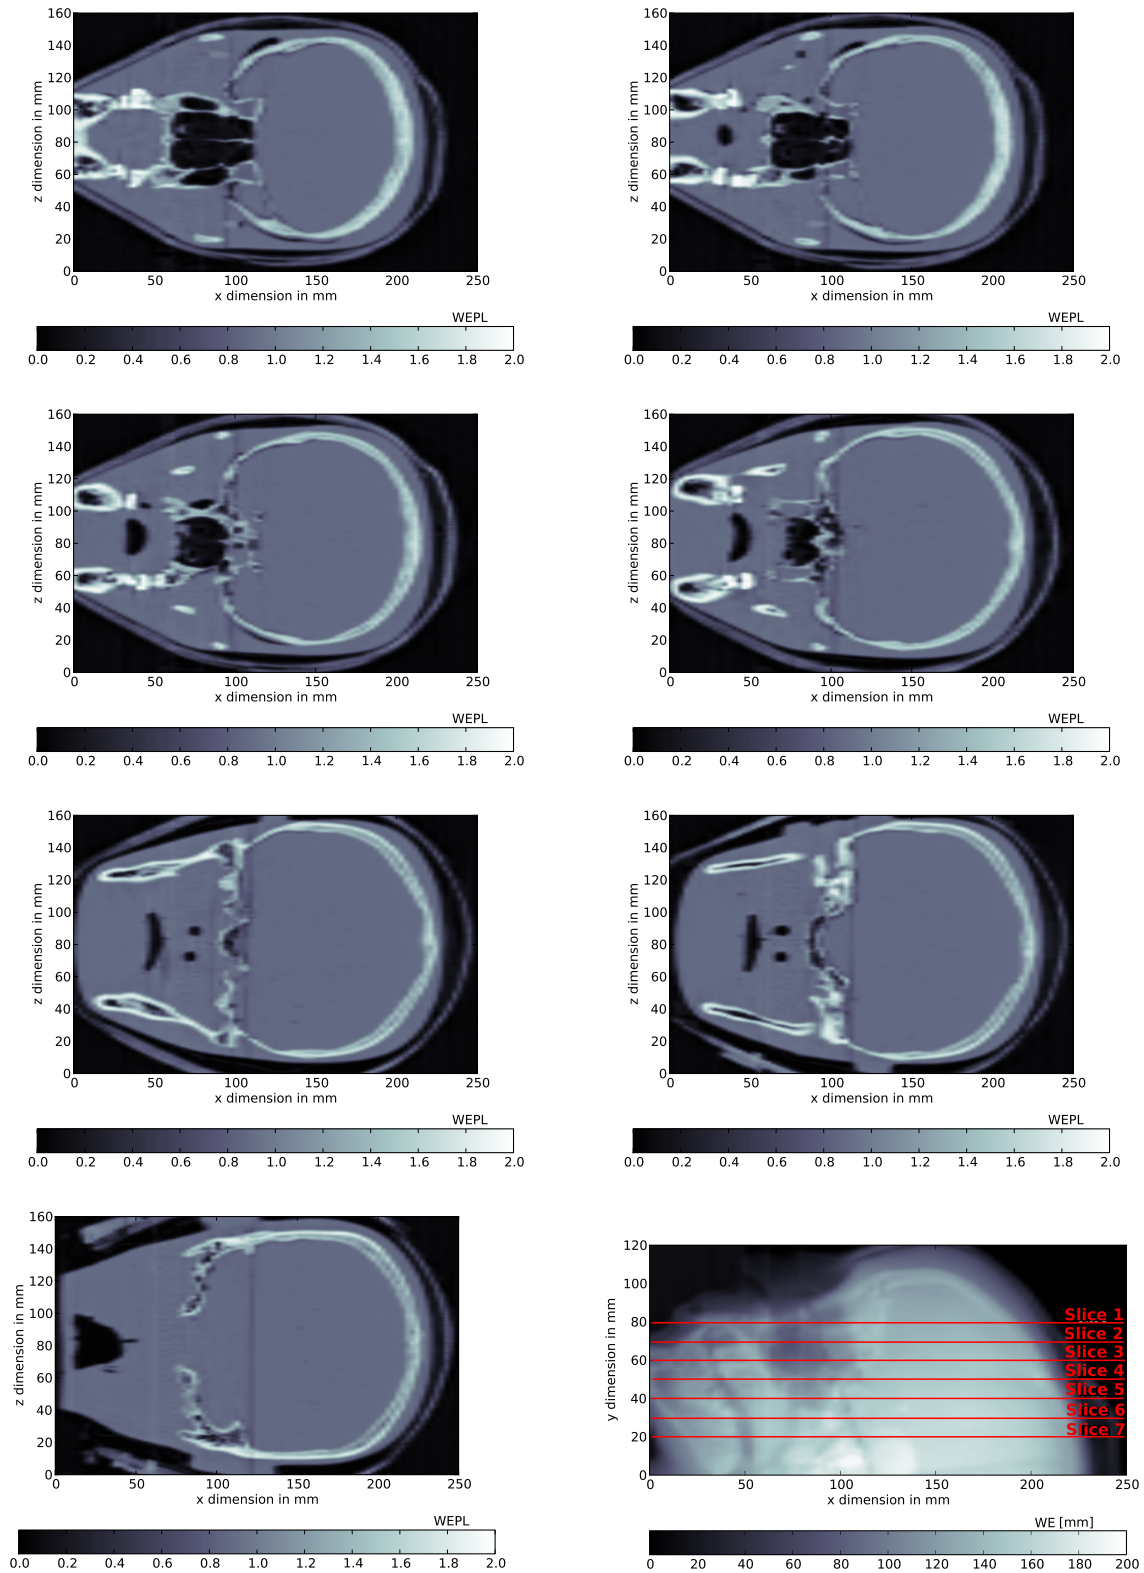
Seven reconstructed slices at 10 mm distance, as shown in the bottom right panel, of the anthropomorphic Alderson head form obtained with an X-ray CT. The colorbar indicates WEPL.
